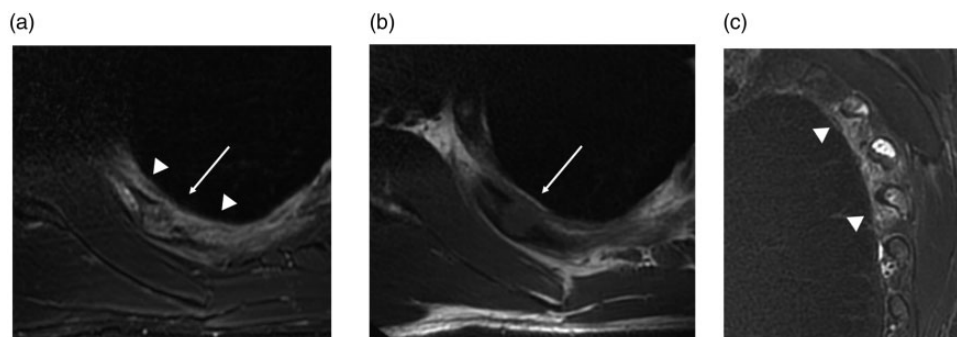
Magnetic resonance imaging. (a) Fat-suppression T2WI, axial image (Repetition Time (TR)=3000 ms, Echo Time (TE)=89 ms). (b) T1WI, axial image (TR=534 ms, TE=12.5 ms). (c) Fat-suppression T2WI, Sagittal image (TR=9592 ms, TE=100.4 ms). MRI showed non-uniform high signal on fat-suppression T2WI (a, arrow) and low signal on T1WI (b, arrow). The surrounding soft tissue showed a low signal at T1WI and a high signal at T2WI, suggesting edematous changes. Fat-suppression T2WI showed bone marrow edema on the fourth rib with lesions, and bone marrow edema on the upper and lower ribs (c, arrowhead).
